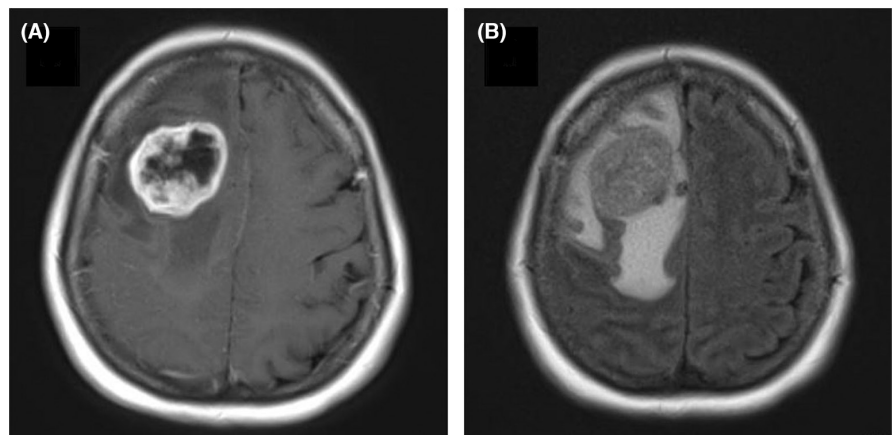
MRI of the brain with metastatic lesion (A) and local edema (B) taken at 17 months.
